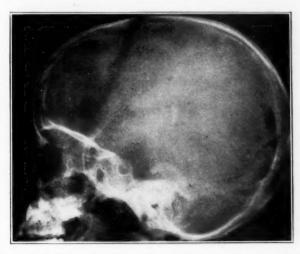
(case 1; P. D.).—Roentgenogram of skull, showing separation of coronal suture. Note two comma-shaped areas of calcification, apparently in the thalami.
